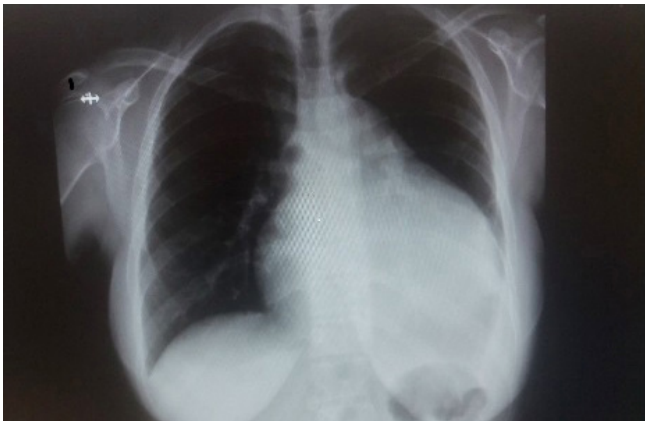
Chest X-ray demonstrating "water-bottle" heart suggestive of pericardial effusion.
